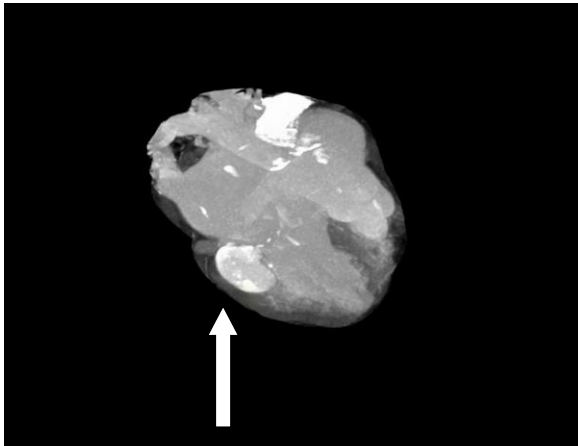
Multislice CT demonstrated the turbulent flow in aneurysm that mimicking mass.
